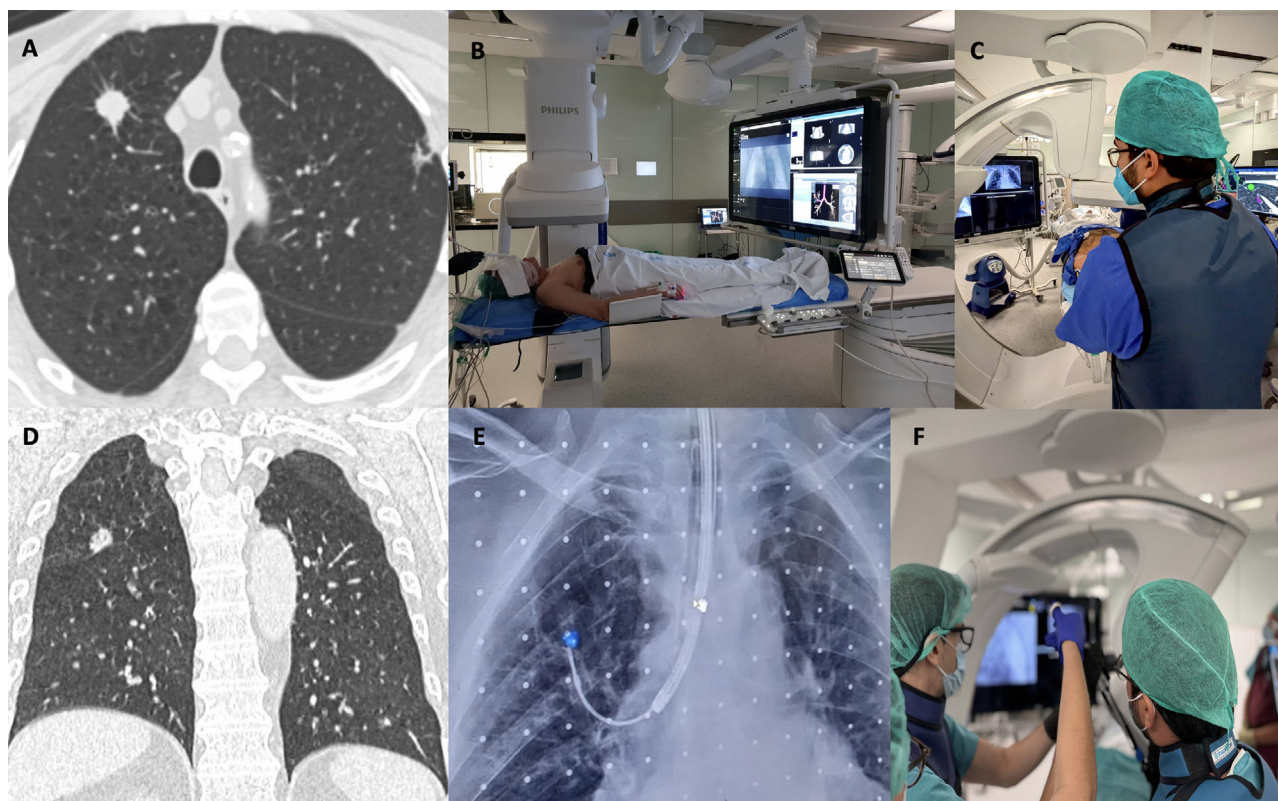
(A) Pulmonary nodule in the RUL on axial chest CT imaging. (B) Hybrid operating room setting. (C) ENB combined with CBCT. (D) Pulmonary nodule in the RUL visualized on coronal chest CT imaging. (E) Augmented fluoroscopy image showing the RUL nodule. (F) ENB combined with CBCT during the diagnostic phase, with transbronchial biopsy sampling.
